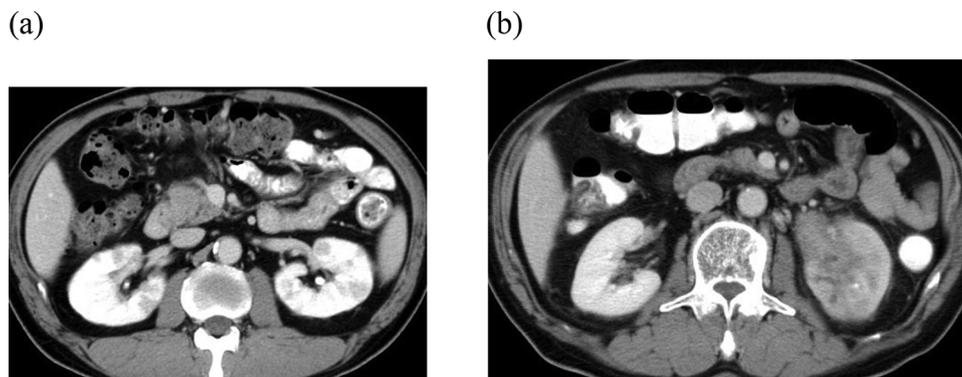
Contrast-enhanced computed tomography of the kidneys in IgG4-RKD.
